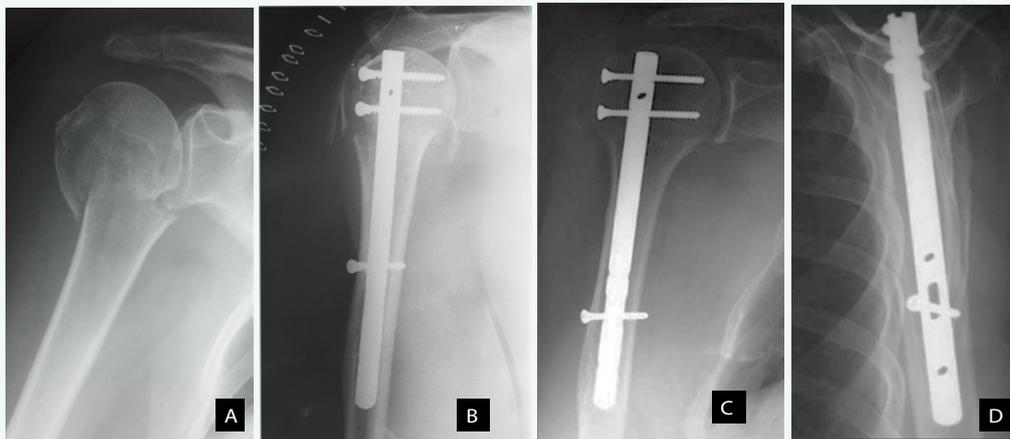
X-ray of the right shoulder. (A) pre-operative frontal incidence showed a 2-parts proximal humerus fracture; (B) immediate post-operative control after Telegraph nail; (C and D) X-ray control at the last follow-up.
